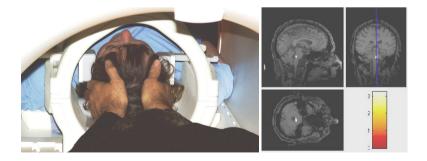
MRI set-up and brain images collected as part of the study. (See full color version at www.performancescience.org.)
